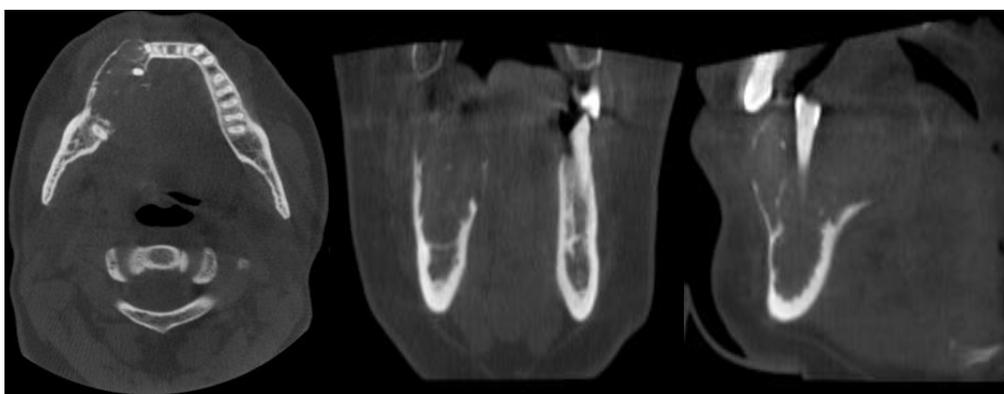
CBCT images showing well defined multilocular hypodense lesion with multiple septations
